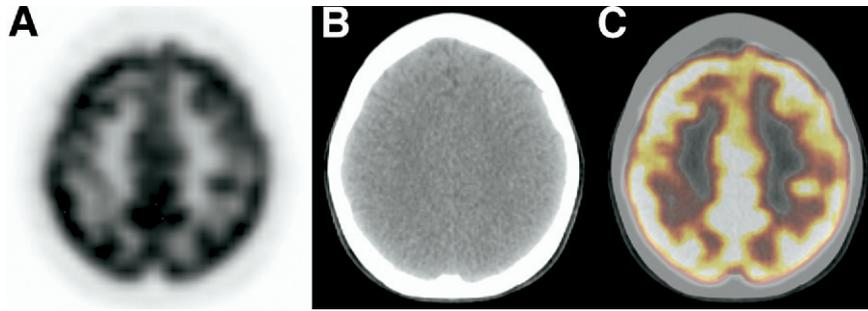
Axial PET (A), CT (B), and fused PET/CT (C) images through frontal lobe of adult brain.
